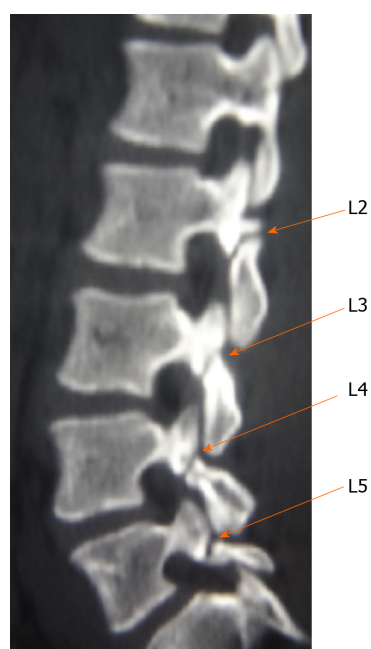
Two-dimensional computed tomography scan shows lumbar spondylolysis at bilateral L2-L5 levels.
